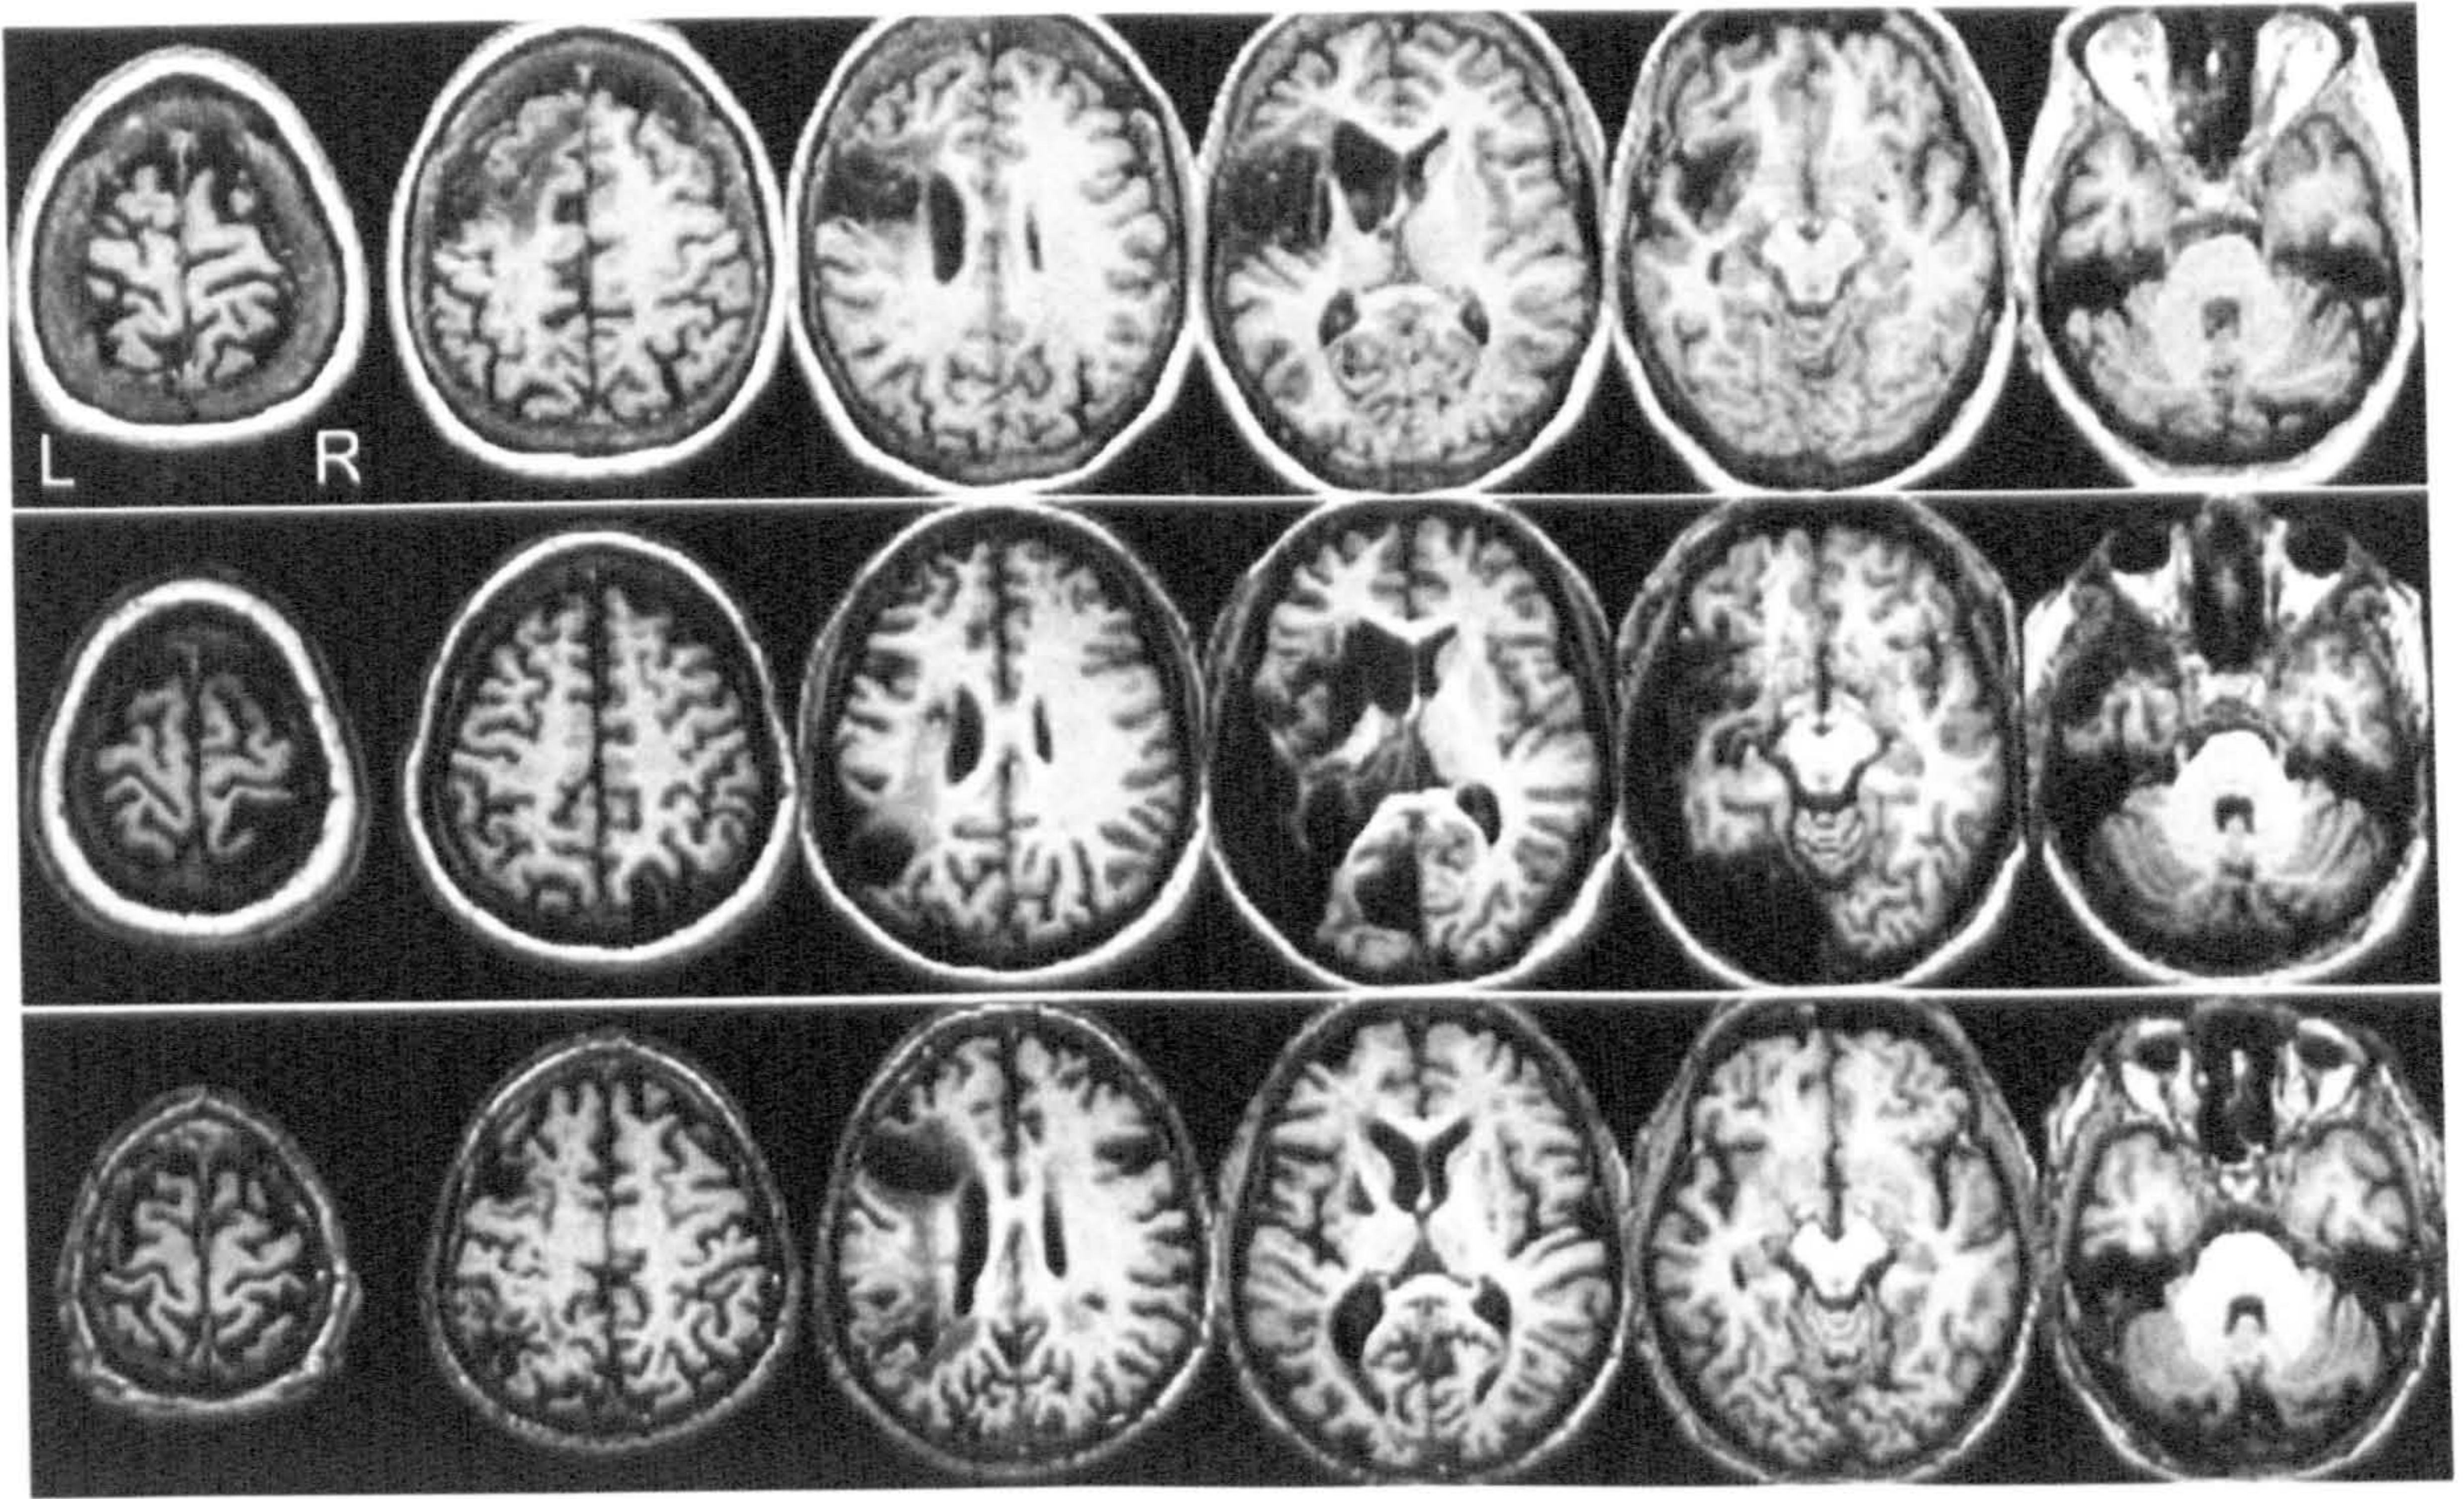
T1-weighted 3D TSE Structural images showing the stroke damage for AP3 (top), AP4 (middle) and AP5 (bottom).
